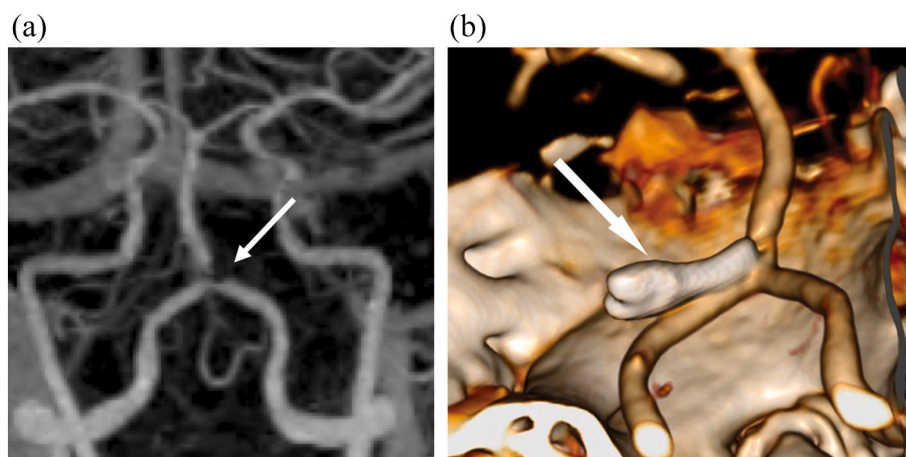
Follow-up imaging by CTA of the clipped VBJ aneurysm. In a) coronal maximum intensity projection of a dual energy CTA with bone subtraction 6 months after treatment. The impression of a proximal basilar flow obstruction is caused by artifact of the Lasic clip (arrow) b) volume rendering (dorsal view) of CTA 5 years after clipping, arrow points to the clip. Both show a complete exclusion of aneurysm.
